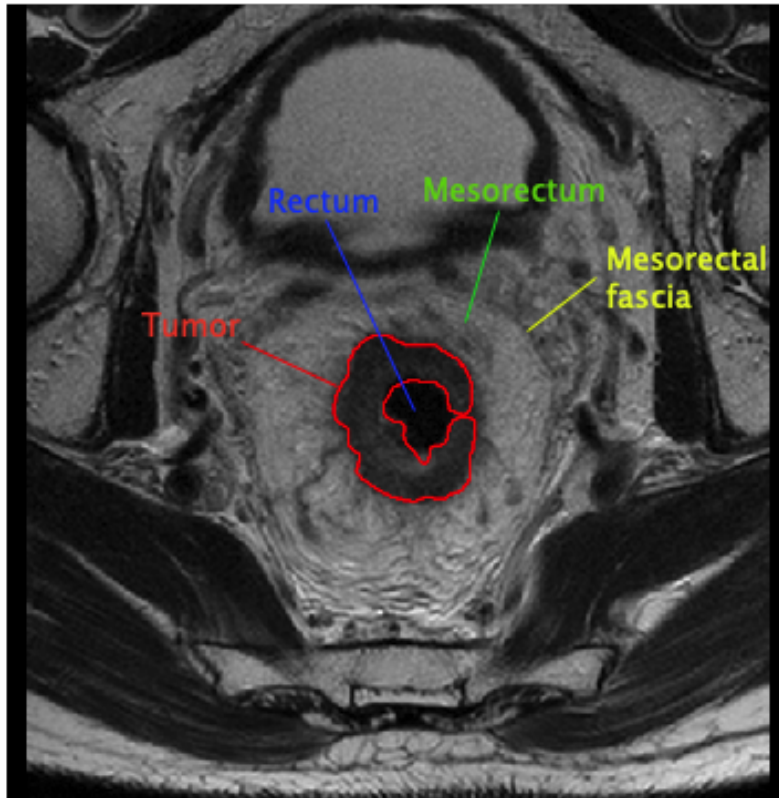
Visualization of rectal cancer in an axial T<sub>2</sub> weighted MR image. The tumor delineation, rectum, mesorectum and mesorectal fascia are denoted.
